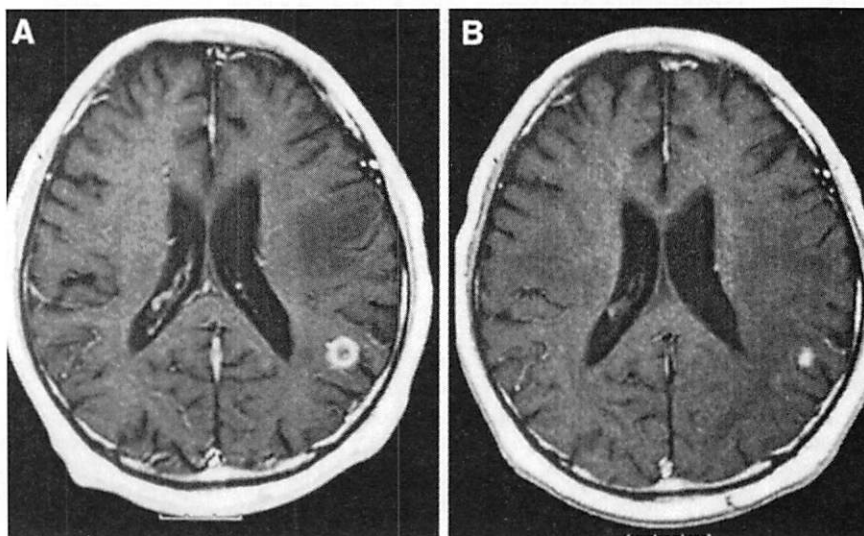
Contrast-enhanced MR images of patient with metastatic lung carcinoma before (A) and 6 mo after (B) stereotactic radiosurgery (patient 2 in Table 1). Significant decrease in tumor size confirmed effectiveness of radiosurgery.
